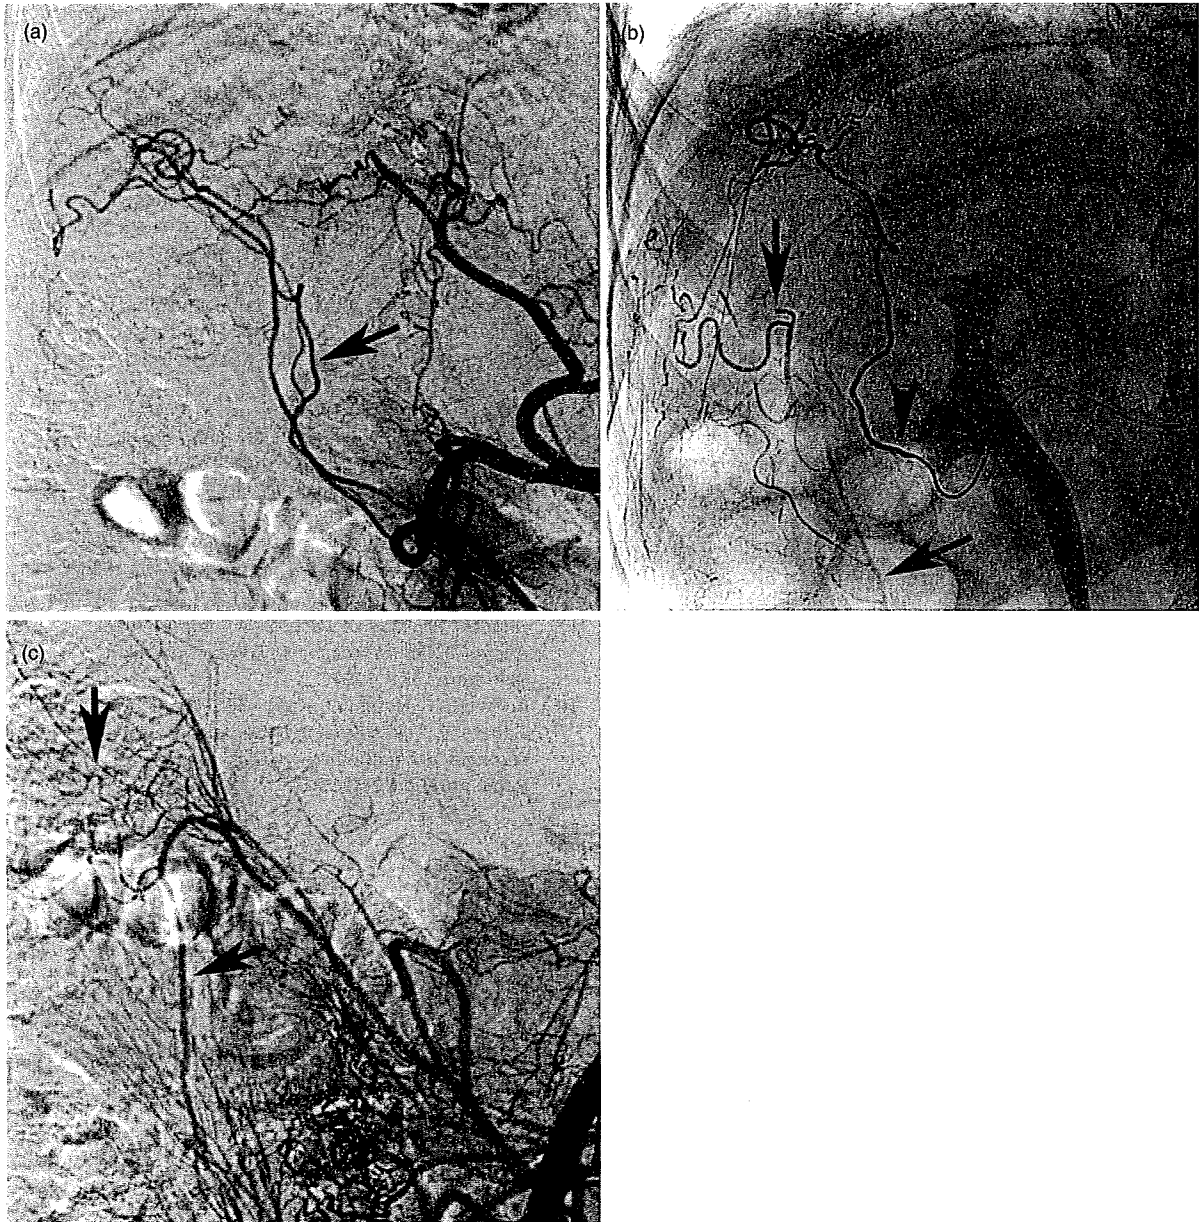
(a) Coeliac arteriogram shows two hypertrophied omental arteries supplying tumour (not shown). One omental artery was selected, and transcatheter arterial chemoembolisation was carried out (arrow). (b) Spot radiograph obtained during chemoembolisation shows retrograde opacification of a vessel that is not seen in (a) (arrows). The arrowhead indicates the microcatheter tip. (c) Arteriogram of the superior mesenteric artery reveals that the vessel is the right colic artery (arrows).
